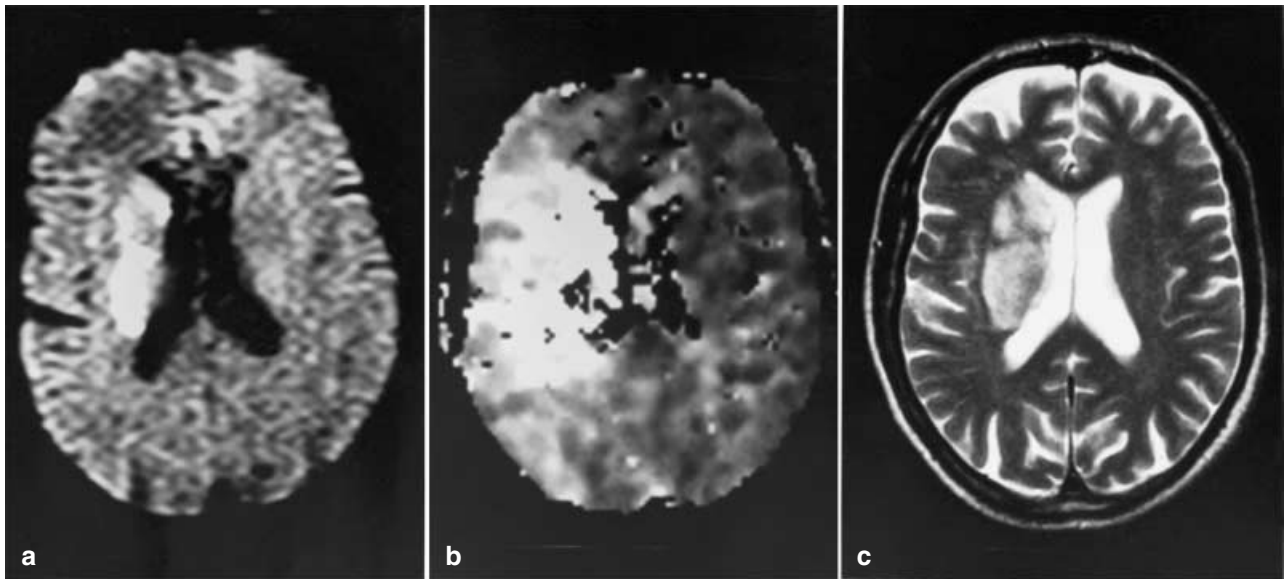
70-Year old patient with acute left sided hemiplegia for about 300 minutes. On initial DWI an enlarge striatocapsular infarct can be detected. On corresponding perfusion parameter maps of the initial imaging study there is an rCBV reduction and severe TTP delay within the hyperintense area of DWI (a) but there is also a remarkable delay of the TTP in the remaining territory of the occluded MCA (b). However collateral blood supply was sufficient in these areas such as no significant infarct growth was observed. On follow-up examinations (day 5), the infarct was still limited to the same striatocapsular region (c)
